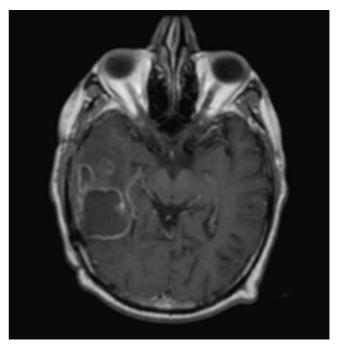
Contrast enhanced axial MRI scan of the brain showing the GBM.
